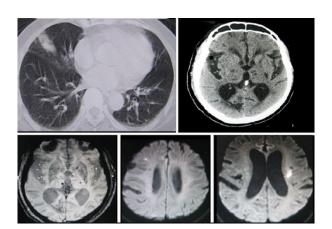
(A-E) is from a 70 year-old male with delirium and cough for 2 days admitted, On admission, chest CT showed pneumonia in the right lung, brain CT showed lacunar infarction in the bilateral basal ganglia. Day 3 of admission, MRI-DWI of brain demonstrated the microbleeding (C) and acute ischemic lesions (D,E) in the bilateral subcortical white matter. After using antibiotics IV, he was discharged from hospital.
